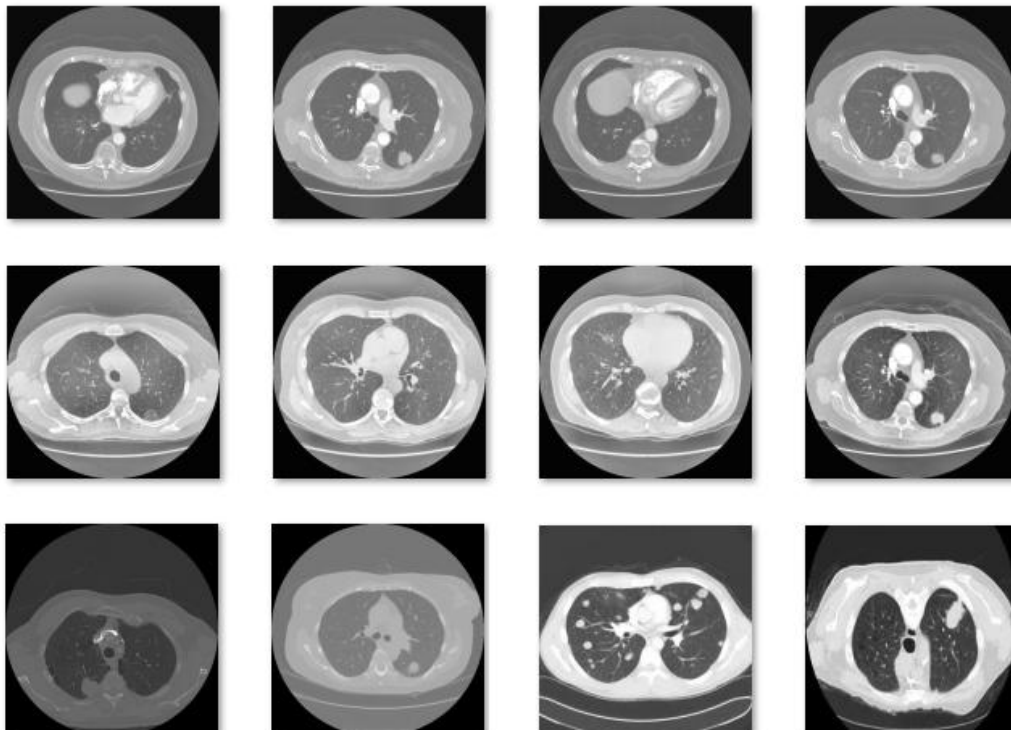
Sample CT Images
